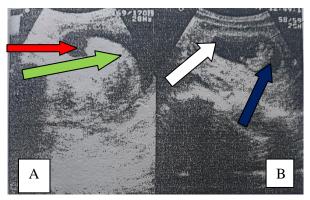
Ultrasonography of intussusception and gravid uterus
